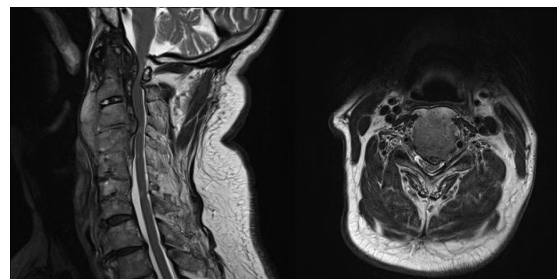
Pre – operative sagittal – enlargement of dens and atlantoaxial joint with calcified thickening of the posterior common ligament resulting in anterior spinal cord compression and coronal MRI reconstruction of the cervical spine showing complete stenosis at C1 level (more on the left side), caused by anterior ossification. Also relative stenosis of C3/4 noted, pronounced on left side
